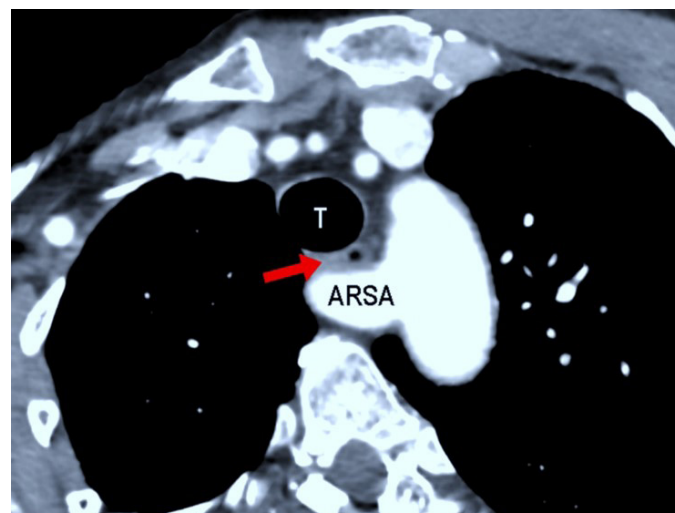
Computed tomography angiography: compression of the esophagus between the aberrant right subclavian artery (ARSA) and the trachea (T).
